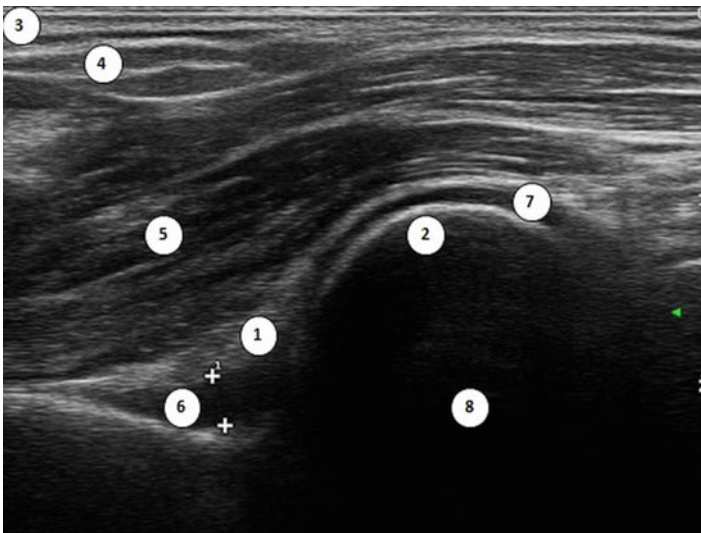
Anterior longitudinal ultrasound image of an elbow with different types of echogenicity: 1. Soft tissue (fat pad)—isoechoic, 2. Bone—hyperechoic, 3. Skin—isoechoic, 4. Fat tissue—hypoechoic with hyperechoic septae, 5. Muscle—hypoechoic with hyperechoic septae, 6. Small amount of intra-articular fluid—anechoic, compressible, 7. Cartilage—anechoic, 8. Area under bone surface—anechoic
